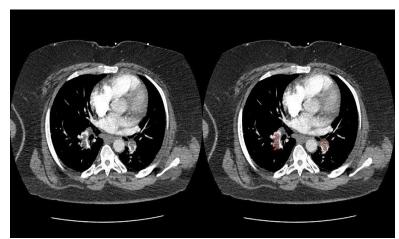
Al algorithm (PEAssist, TeleradTech) demonstrating bilateral pulmonary thromboembolism on a CT Angiogram of the chest performed in a patient with difficulty breathing.
